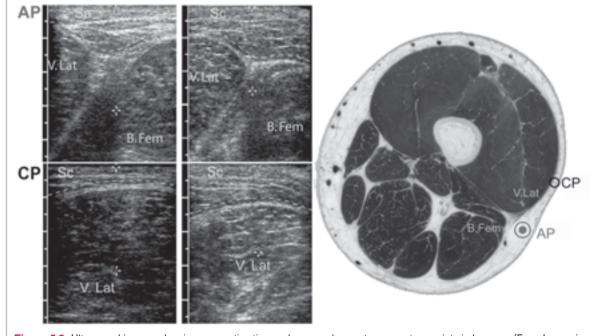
Ultrasound images showing connective tissue cleavage planes at acupuncture points in humans. (From Langevin & Yandow 2002, with permission.)
